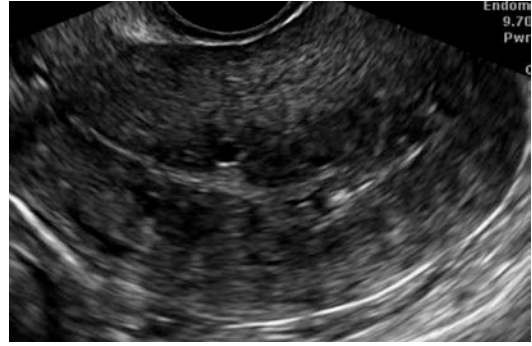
Ultrasound image of adenomyosis: irregular junctional zone
